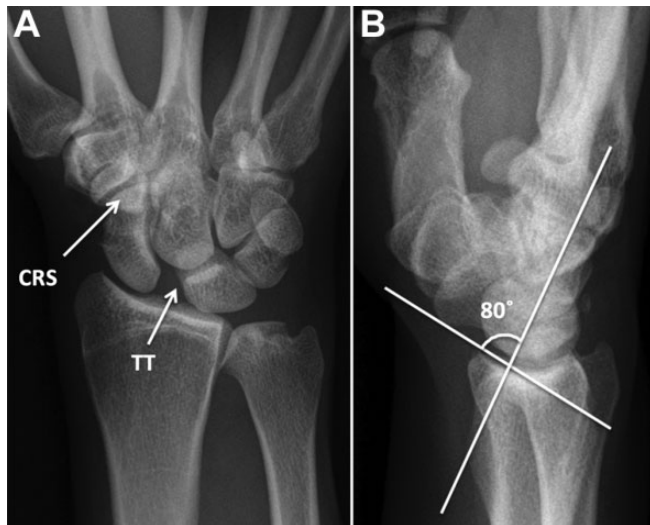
(A) Anteroposterior radiograph showing a widened scapholunate (SL) interval, sometimes referred to as the “Terry Thomas sign” (TT), and malalignment of the scaphoid, with a cortical ring sign (CRS). (B) Lateral radiograph showing dorsal tilt of the lunate. The SL angle is measured from a tangential line along the volar aspect of the distal and proximal pole of the scaphoid and a line through the midaxis of the lunate. Here the SL angle is approximately 80°; angles >70° are indicative of a complete tear of the SL ligament. (Reproduced with permission from Rajan PV, Day CS. Scapholunate interosseous ligament anatomy and biomechanics. *J Hand Surg Am.* 2015;40[8]:1692-1702.)
